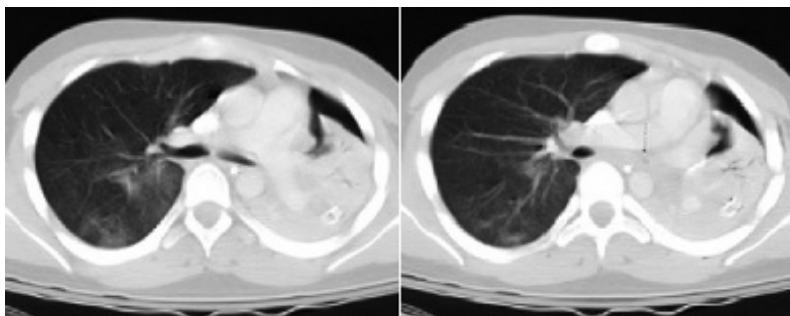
Fifteen-year-old male ATV crash presented with left pneumothorax and pneumomediastinum. There was persistent pneumothorax and air leak despite two well-placed chest tubes. CT scan showed abrupt cutoff of the left mainstem bronchus posterior to the left pulmonary artery and fluid-filled central bronchi. He underwent sleeve resection of the left mainstem bronchus and a primary bronchial repair.
